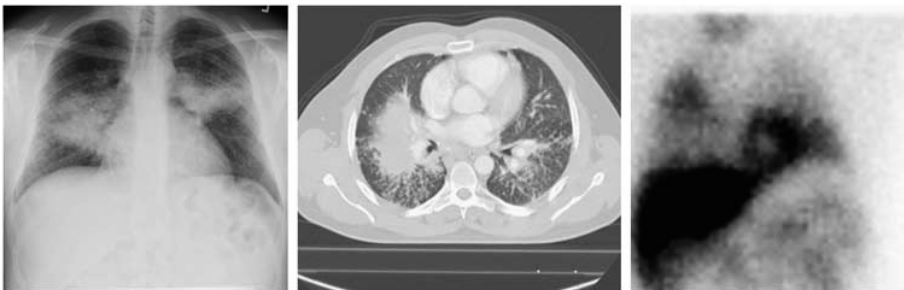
Metaiodobenzylguanidine and sarcoidosis. Anterior chest radiograph, transaxial CT slice and planar anterior image of the thorax made of a patient with active sarcoidosis disease 4 h after intravenous injection of 185 Mbq ¹²³I-metaiodobenzylguanidine (MIBG). Note the remarkable irregular distribution of MIBG in the lungs.
